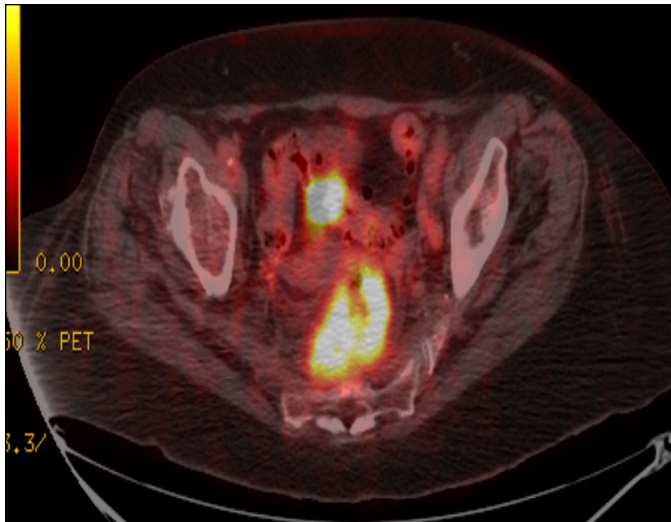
PET/CT to further stage her lung cancer showed a marked increase in uptake of radionuclide deep in the rectosigmoid colonic area.
